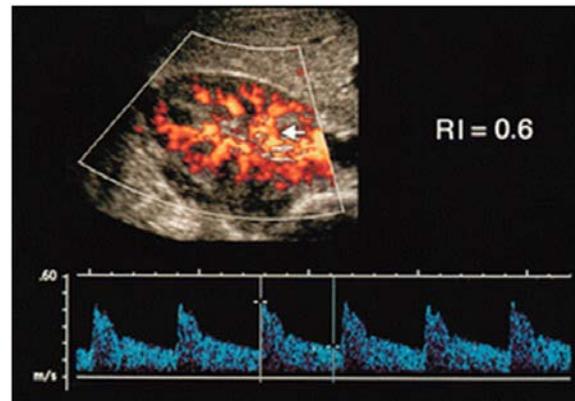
Normal resistive index in a 25-year-old healthy woman. Color Doppler sonogram is used to identify inter-lobar artery (arrow); waveform is maximized using lowest pulse repetition frequency possible
